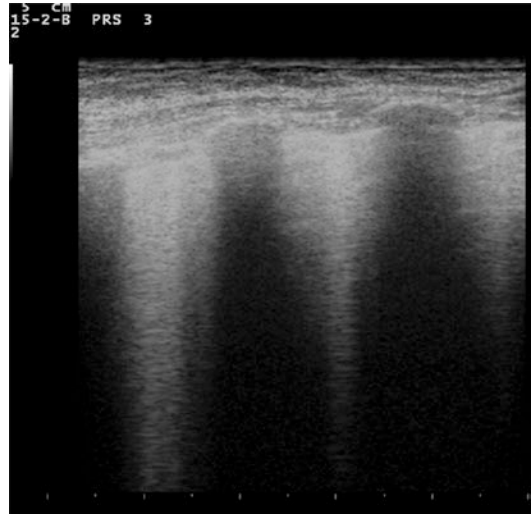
Car crush: at lung ultrasound, anterior, bilateral, confluent B-Lines. The B-lines are “ring-down” artifacts that originate from the pleural line with vertical propagation
